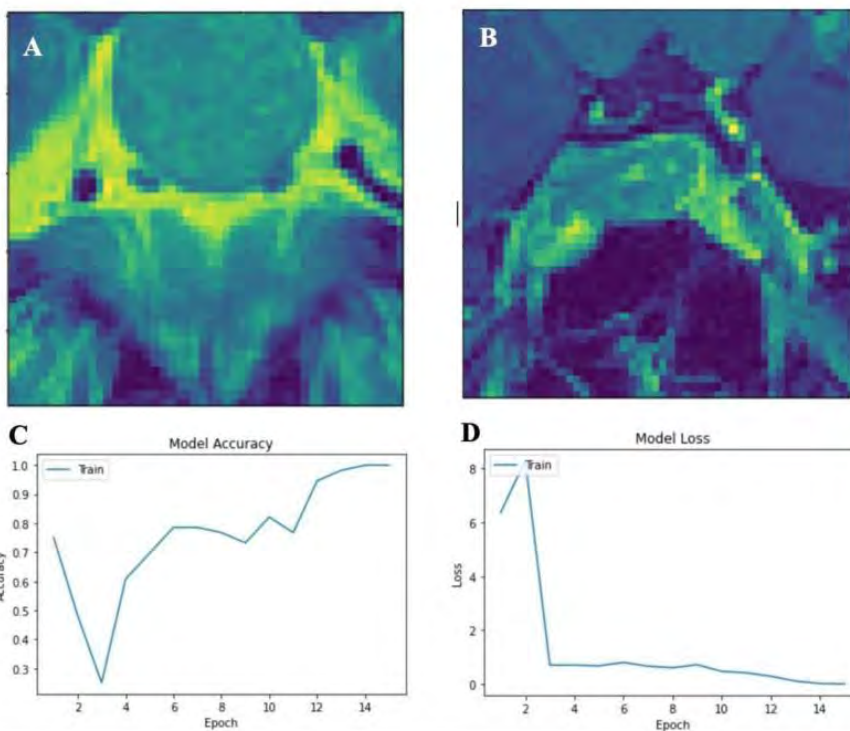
Grayscale, normalized, cropped (50X50 pix) stereotactic post-contrast MRI slices of (A) a larger pituitary macroadenoma without CSI and (B) a pituitary macroadenoma with CSI. Additionally, statistical evidence of the model converging over 15 iterations is shown in (C) graph of consistent increase in accuracy reaching close to 90% at iteration 12 and (D) Graph of relative categorical loss over iterations; showing plateau at iteration 3.
